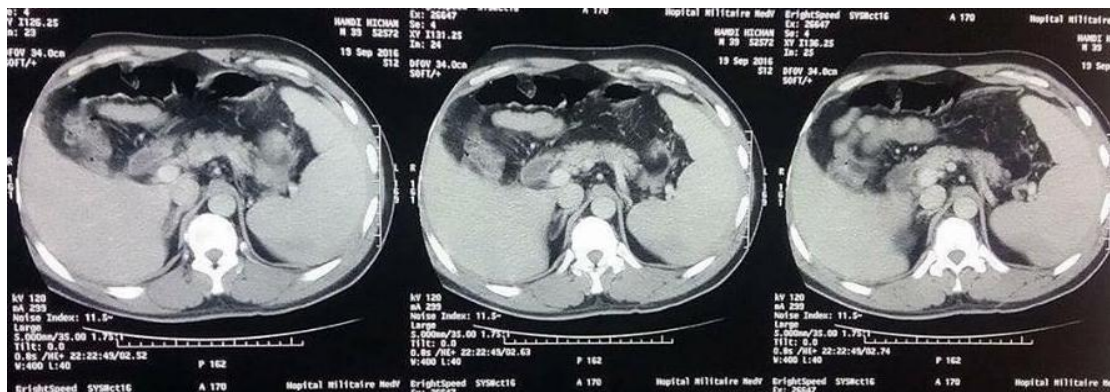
Abdominal CT-scan; splenomegaly and perisplenic hematoma.
